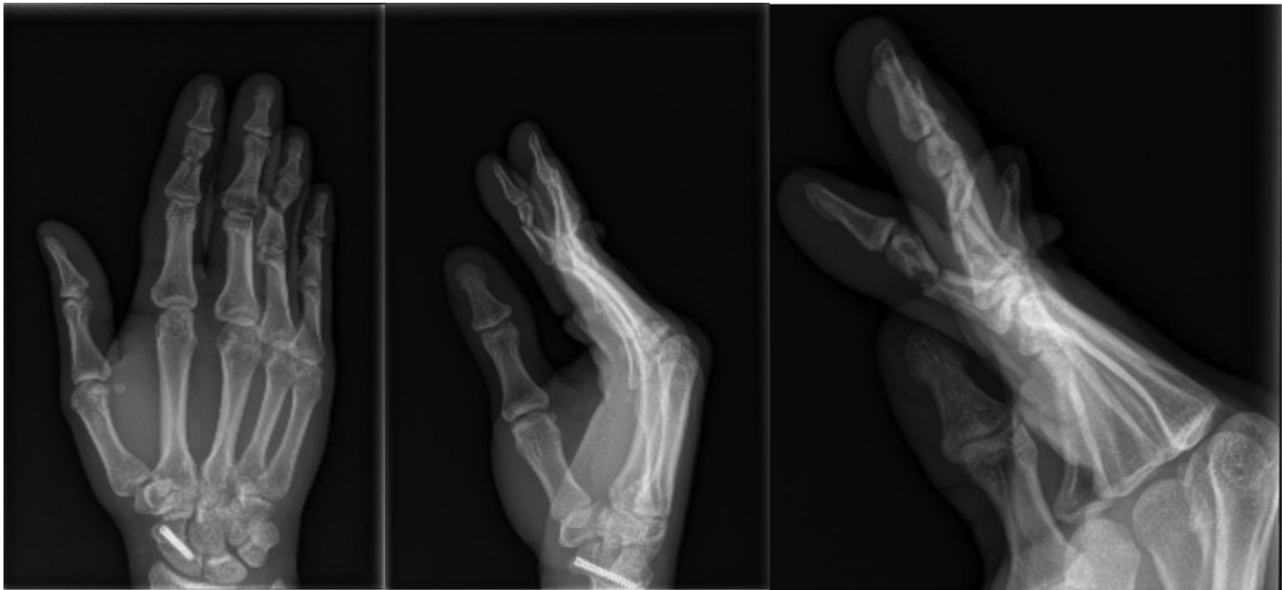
Preoperative radiographs of displaced ring and index middle phalangeal fractures requiring fixation.
